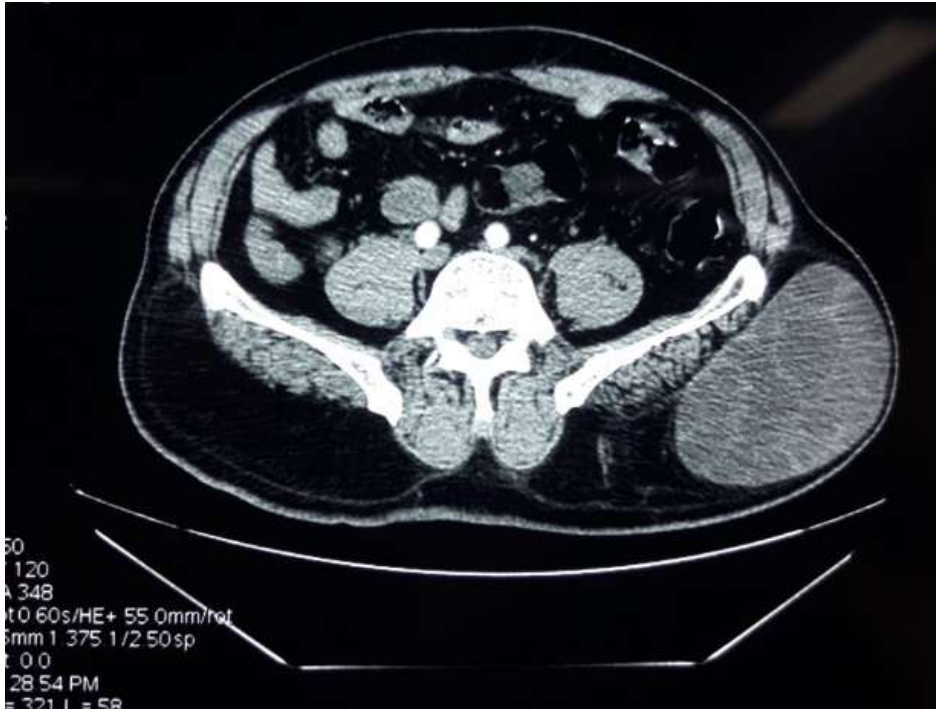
CT Of the pelvis: aspect of subcutaneous hydatid cyst of gluteal area
